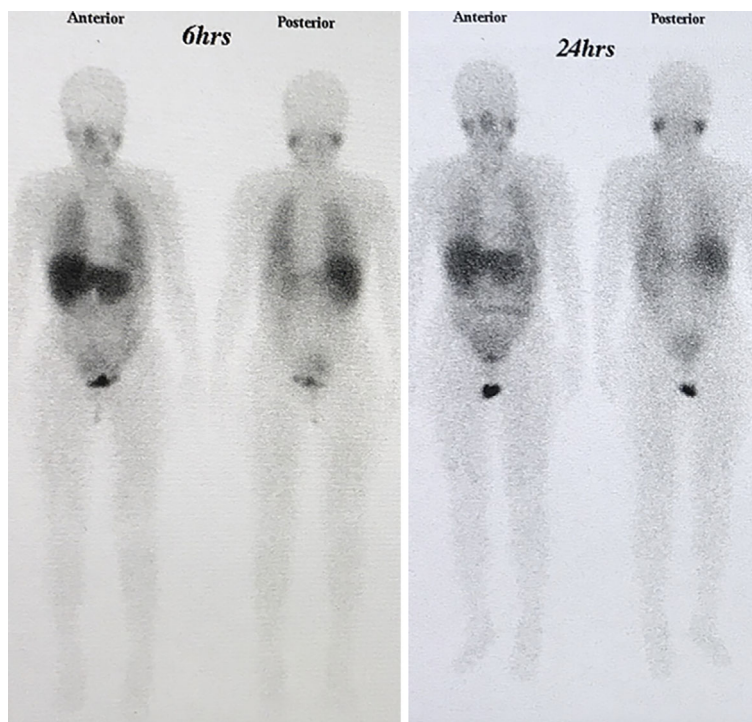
^{123}I -metaiodobenzylguanidine scintigraphy. Scintigrams of the whole body showing no abnormal accumulation of the radioisotope in the cervix or abdomen, indicating the development of neither recurrent pheochromocytoma nor paraganglioma.
